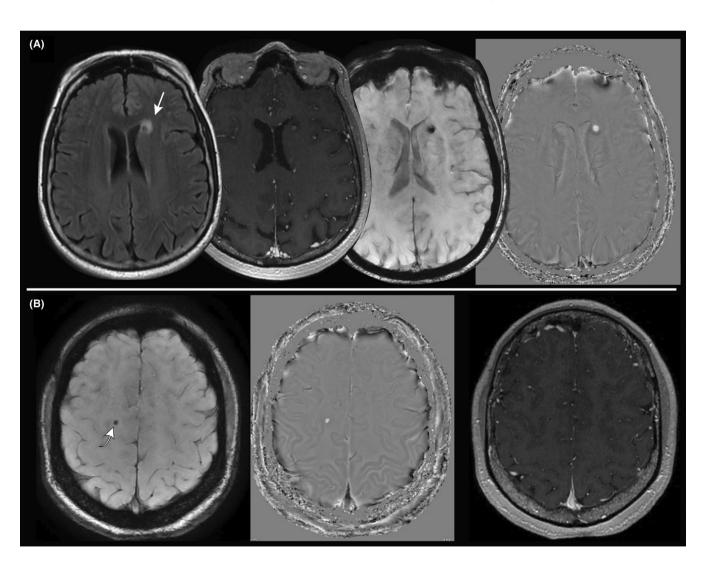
Examples of late-stage NCC lesions. (A) Granulomatous lesion adjacent to the lateral ventricle with some perilesional edema on FLAIR (leftmost image; arrow), no signal enhancement after contrast administration (second image from the left), and signs of calcifications on SWI (hypointensity, third image from the left) and the corresponding phase map (hyperintensity, rightmost image). (B) Calcified lesion seen as hypointense on SWI (left; curved arrow) and hyperintense on the corresponding phase map (middle), without contrast enhancement (right).
